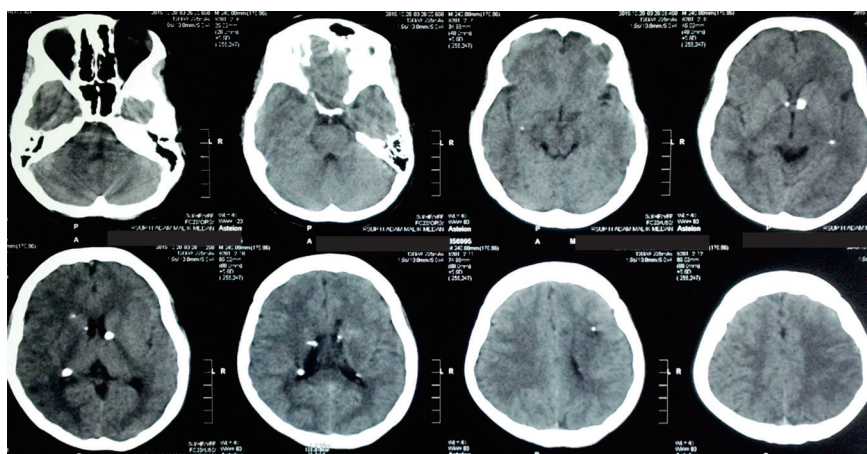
Multiple Calcification on Non-contrast Head CT
